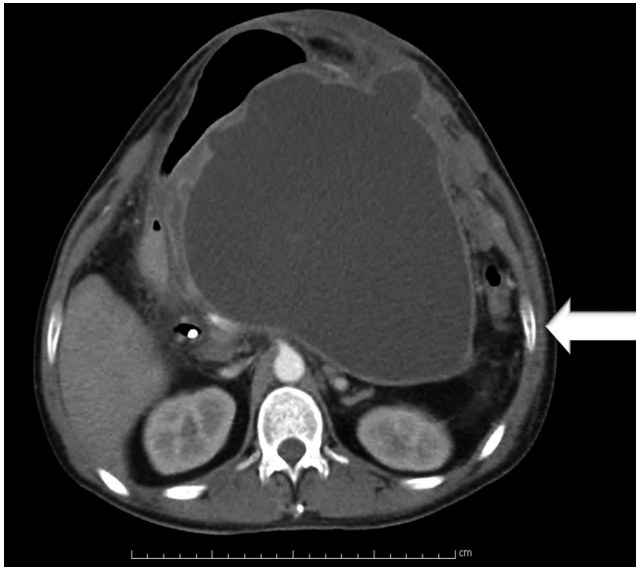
Abdominal CT scan with contrast. The arrow points to the pancreatic pseudocyst.
